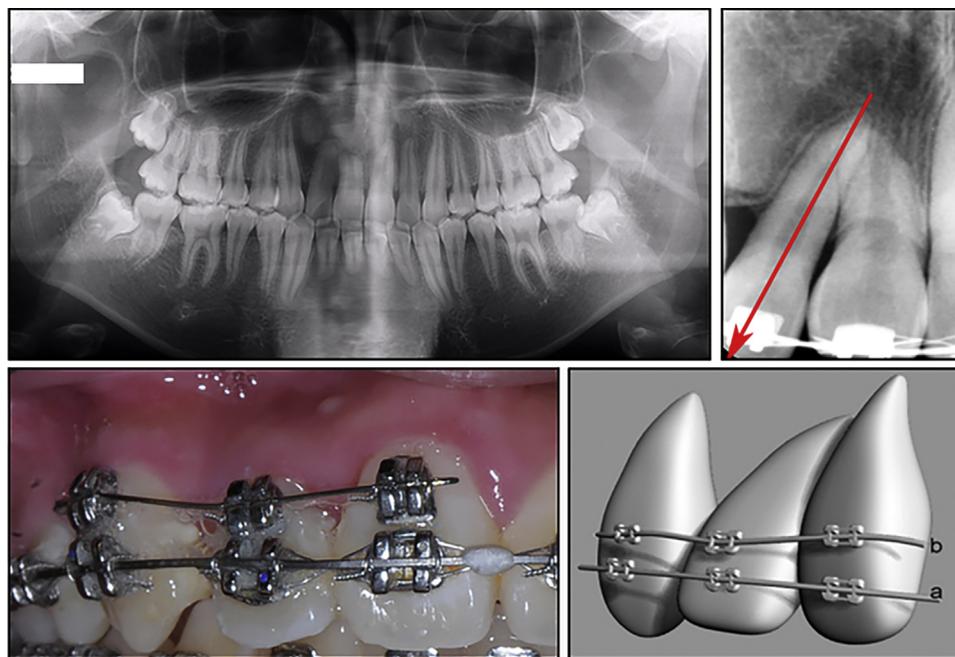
A, Panoramic radiograph at the 2-year follow-up. B-D, The biomechanics used for torque control.
